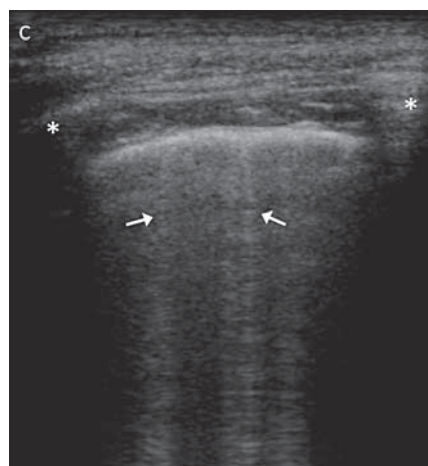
A 13-year-old male with fever and productive cough. A sagittal sonographic scan of the right fourth intercostal space on the midclavicular line was performed in the upright position using a linear transducer (7.5 MHz) in B-mode. Focal B-lines are highlighted by arrows. This finding represents the sonographic appearance of perilesional inflammatory edema. The asterisks mark the upper and lower rib. C = Cephalic.
